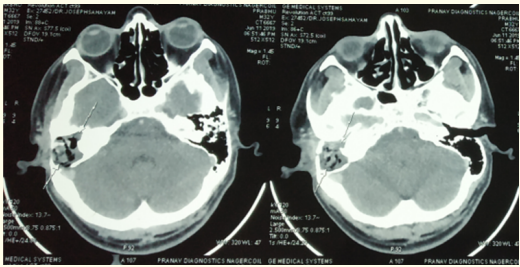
HRCT temporal bone showing soft tissue density in middle ear and mastoid.
